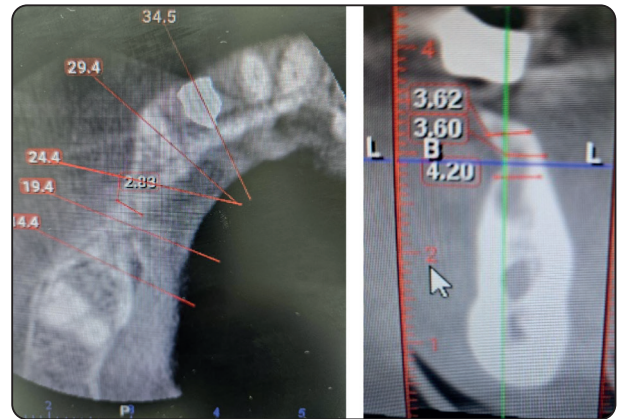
Preoperative CBCT image showing horizontal alveolar ridge deficiency the measurement of the ridge requiring augmentation (2.83 mm)
